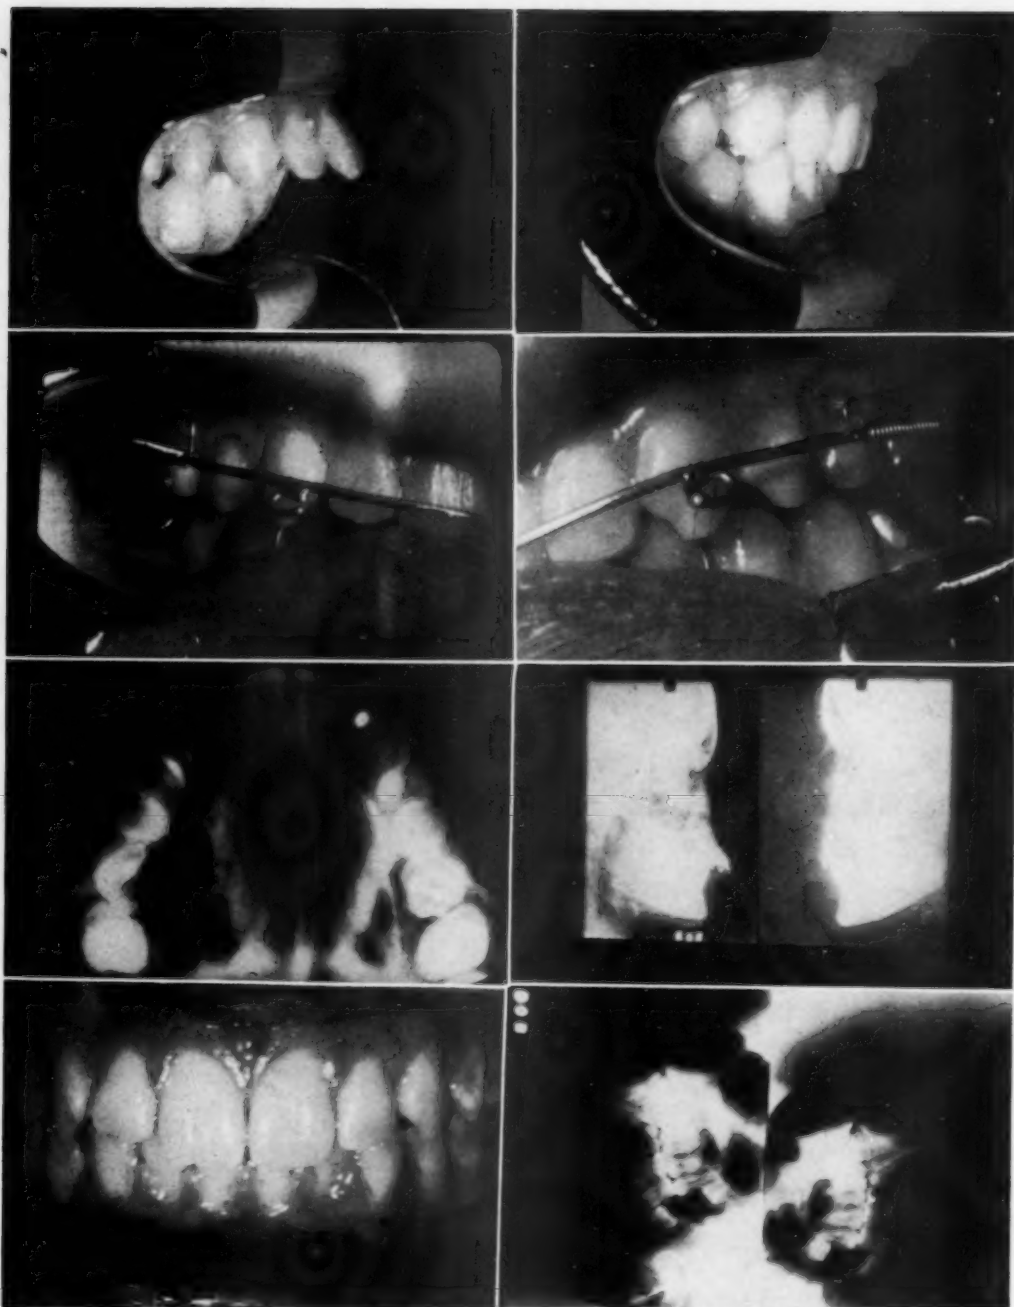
Showing profile oral before treatment and after retraction of incisors, distal movement of buccal segments after placing coil springs, occlusal x-ray showing corrected relation of maxillary first permanent molars to key ridge, profile before and after treatment with no apparent increase in axial inclination or forward displacement of mandibular incisors, full face oral after treatment, and third molars erupting normally.
